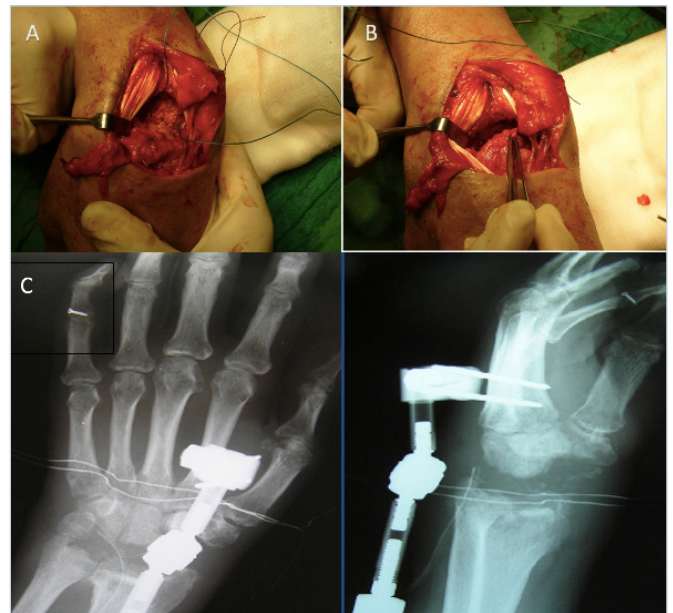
(A) Surgical image showing volar capsule after removal of the proximal row; (B) Distal based capsular flap including the interosseous dorsal ligament for the capitate and proximal based capsular flap for the lunate fossa; (C) Postoperative X-ray after proximal row carpectomy and external fixation.
